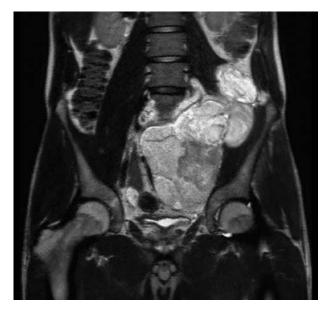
T2-weighted magnetic resonance image of a primary retroperitoneal MLS.
